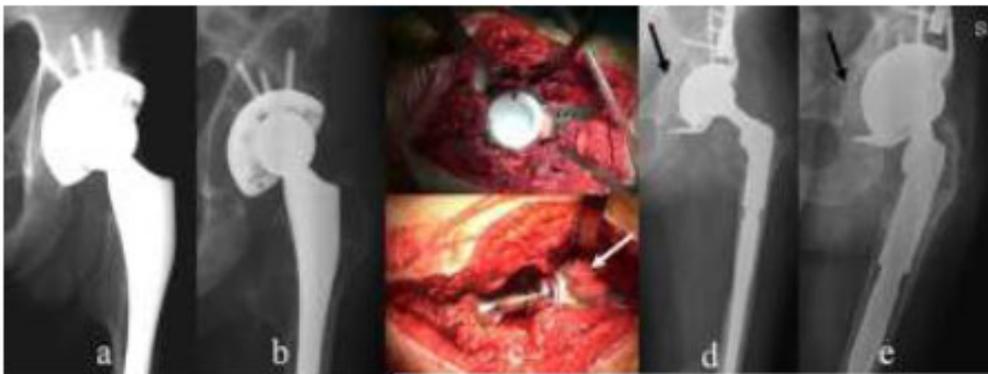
Ceramic-on-PolyEthylene primary THA in a 41-years old subject affected by Haemophilia A with inhibitors (a) . Five years later, aseptic loosening with gross osteolysis in the acetabular and femoral components (b) . Revision with a trabecular metal cage, heterologous bone grafts enriched by autologous stem cells concentrate (white arrow), and a Metal-on-PolyEthylene coupling (c) . Postoperative x-rays at 6 months (d) and two years after surgery (e) with evidence of progressive osseointegration of bone grafts.
